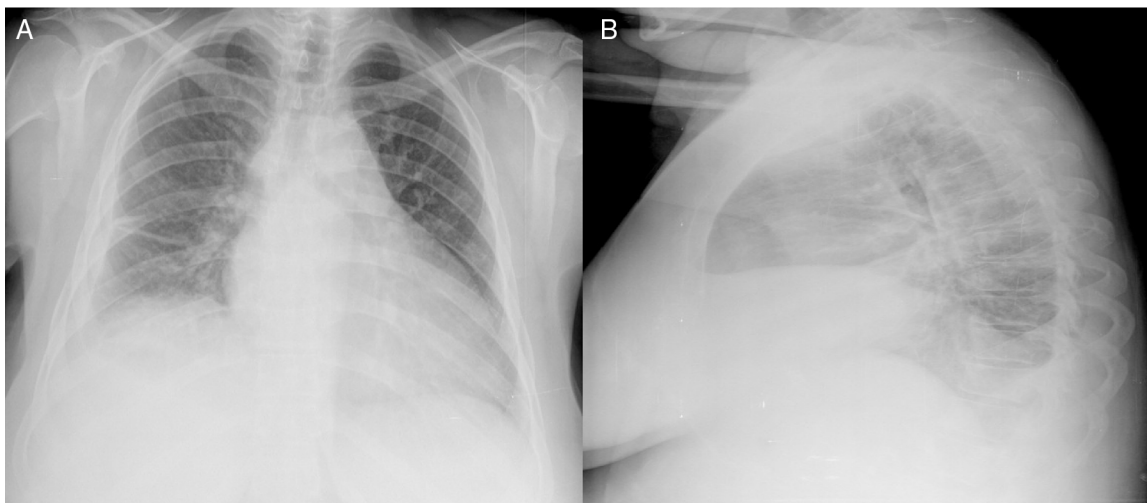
Chest radiograph.
